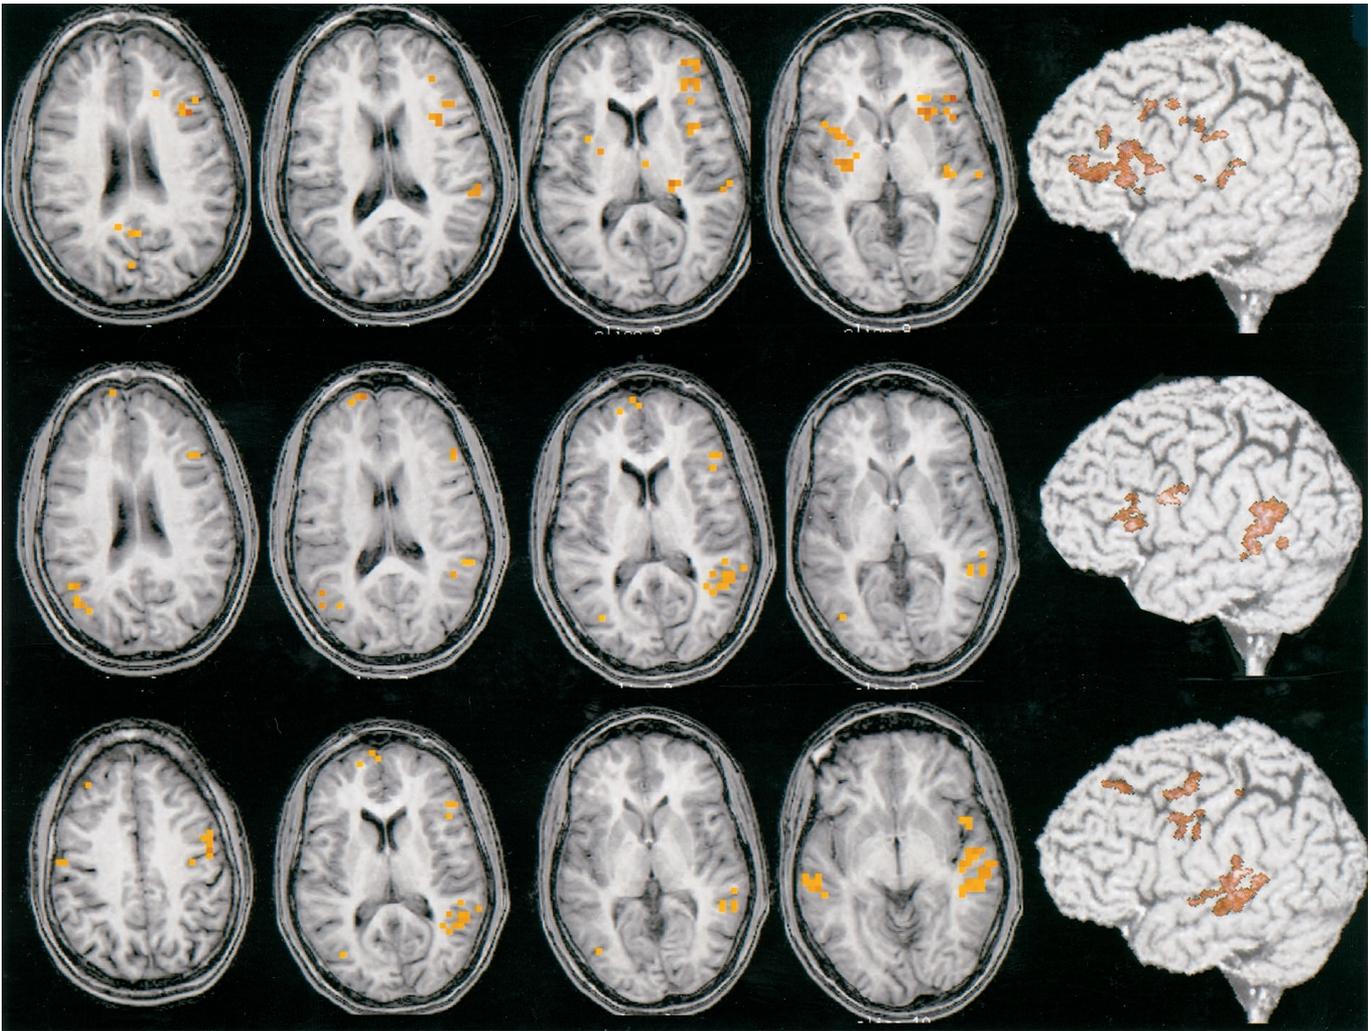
Functional images of Patient 3 performing the semantic fluency (upper row), the story listening (middle row), and the covert repetition tasks (lower row). Activated pixels are overlaid on axial anatomic images (inversion recovery T1-weighted) and on a three-dimensional surface rendering of the left hemisphere (right).
